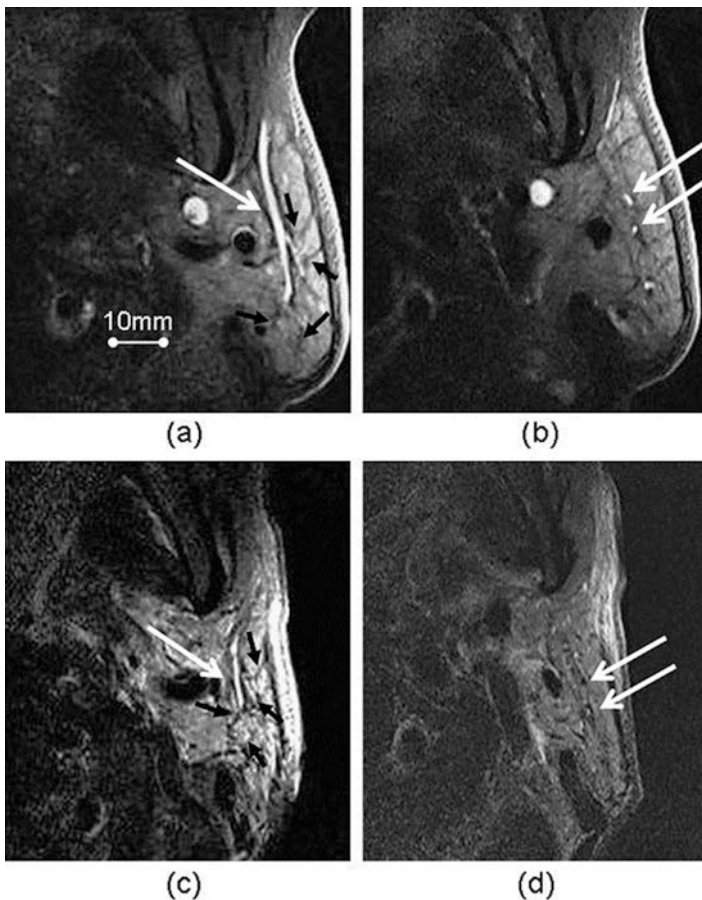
MRI evaluation of parotid gland prior to RT (*top*) and post RT (*bottom*), showing reduction in cross-sectional volume and duct width [41]
